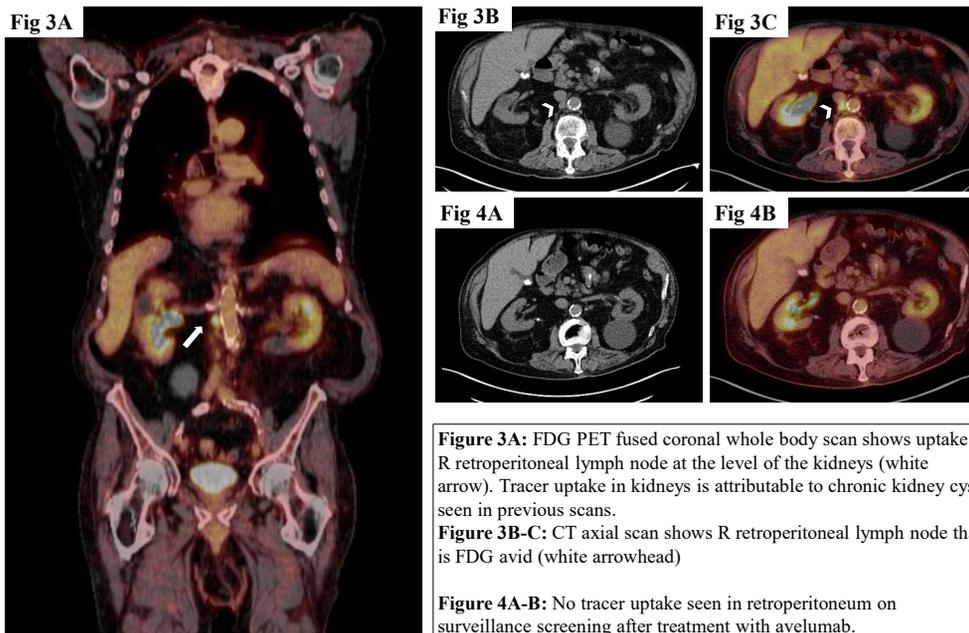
FDG PET fused coronal whole body scan shows uptake in R retroperitoneal lymph node at the level of the kidneys (white arrow). Tracer uptake in kidneys is attributable to chronic kidney cysts seen in previous scans.
